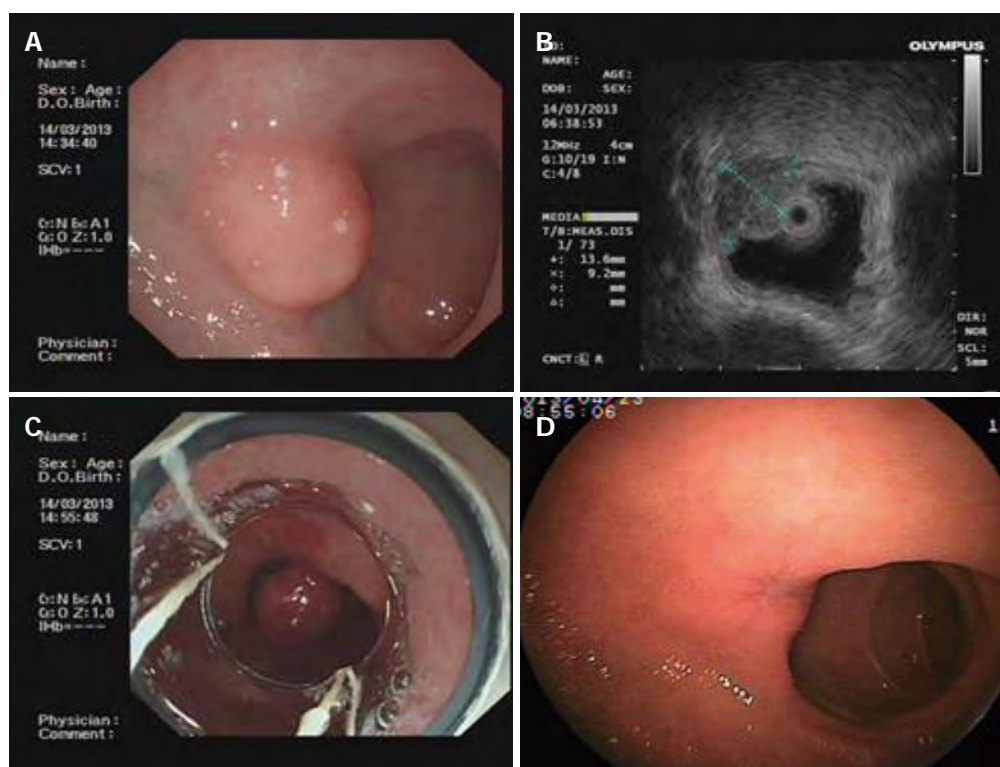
Imaging in case 3. A: Endoscopic view of the protuberant lesion in the duodenal bulb; B: Endoscopic ultrasonography image of the size of the lesion; C: Endoscopic view of the ligated lesion using the endoscopic variceal ligation device; D: Endoscopic view of an ulcer scar at the ligation site after 6 wk.
